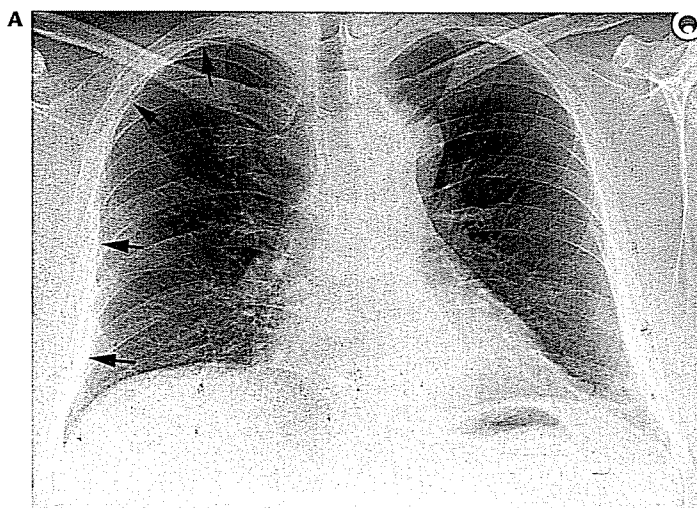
Extrapleural fat. A, Chest radiograph shows soft tissue thickening extending in an undulating fashion all the way to the apices (arrows). The costophrenic sulci are not involved. B, CT confirms extrapleural fat (arrows).
